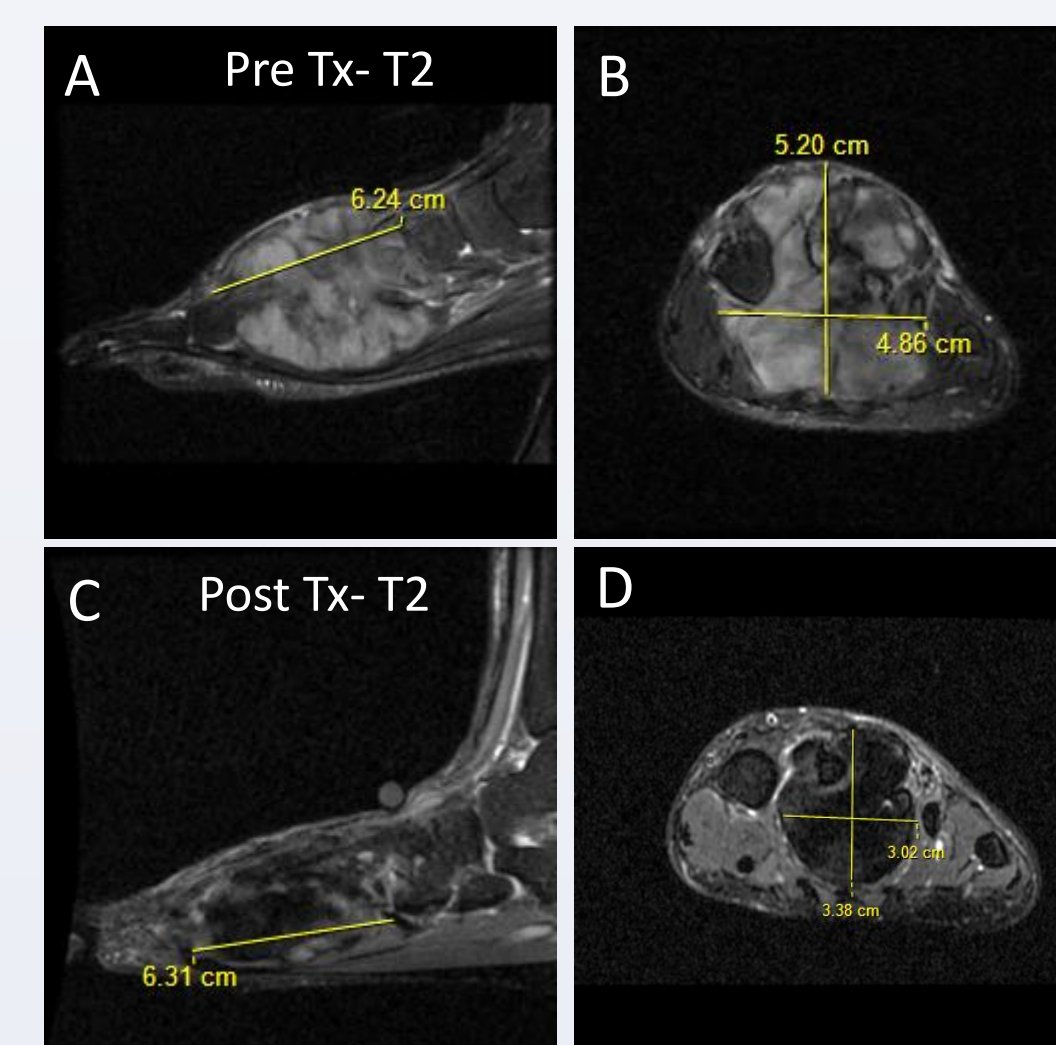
T2-fat-saturated sagittal and coronal MRI images of DF in L foot pre- and post MTX/VIN.
